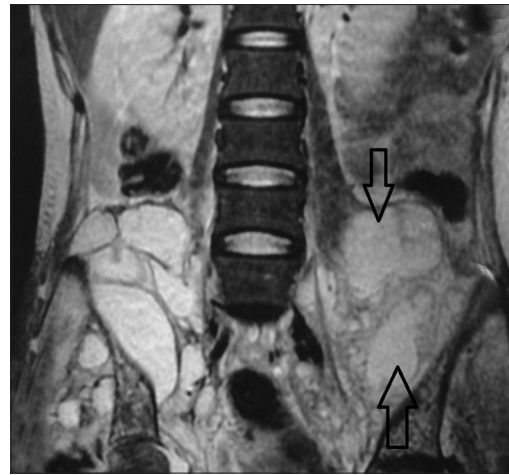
T1 weighted magnetic resonance imaging image showing hypointense lesions involving the left iliopsoas muscle (arrow)
